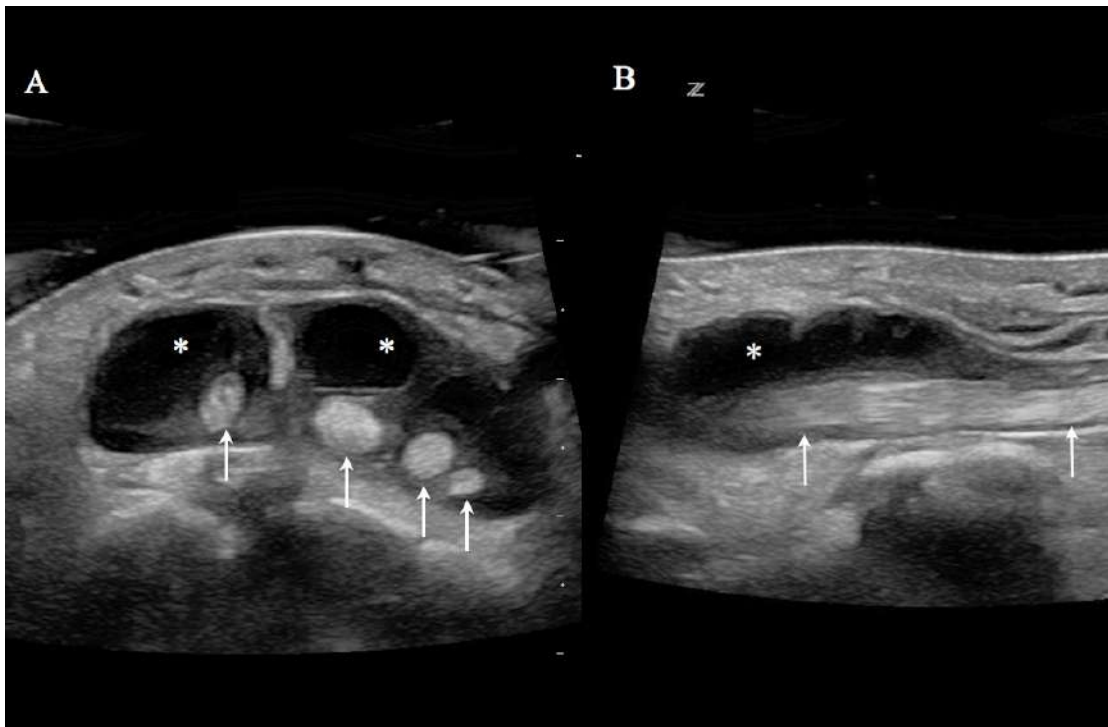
Ultrasound with water bath of a patient with extensor tenosynovitis of the hand due to intravenous drug use. (A) Transverse view of the left hand with fluid collection (asterisk) surrounding the dorsum of the second to fifth digit extensor tendons (arrows). (B) Longitudinal view of the third-digit extensor tendon. Fluid collection (asterisk) surrounding the tendon (arrows).
